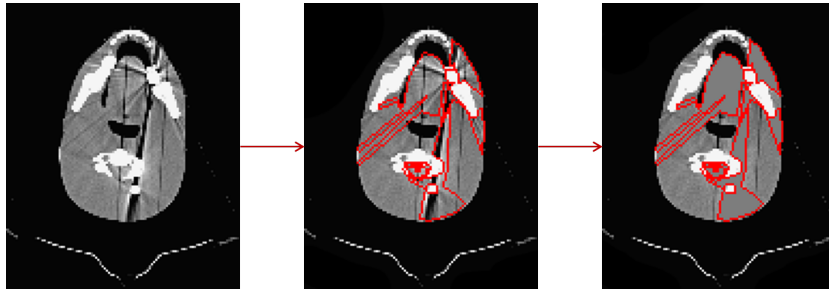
Procedure of manual correction of a slice of Charlie's CT: the doctor delineates the regions affected by the artifact and replaces these HUs with the mean CT number of the surrounding soft tissue.
